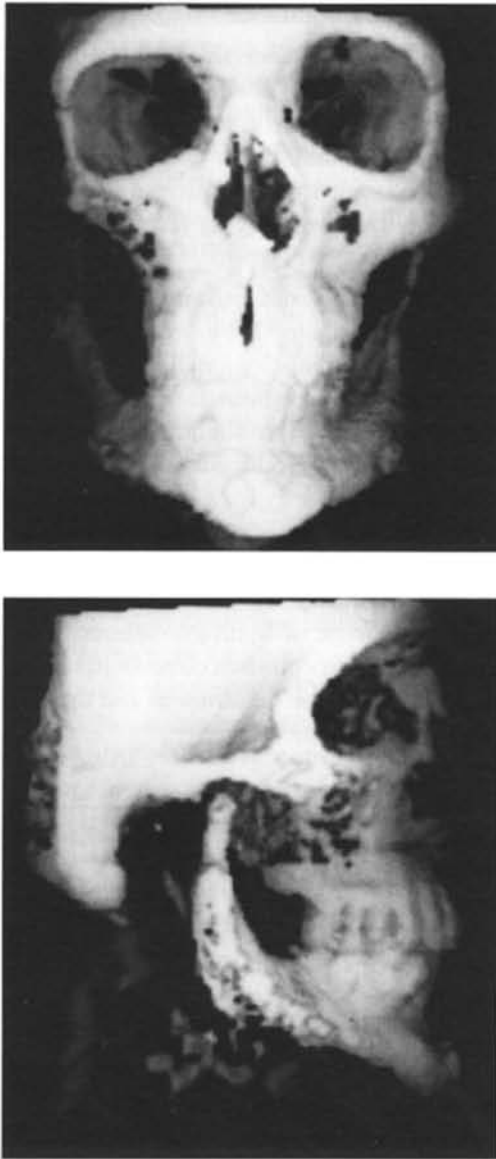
Frontal (7a) and lateral (7b) 3D reformatted CT reconstructions of an 18 year old Hispanic patient demonstrating hemifacial microsomia (Goldenhar's Syndrome). (Courtesy of Dr. Marden Alder, University of Texas Health Science Center at San Antonio, TX).
